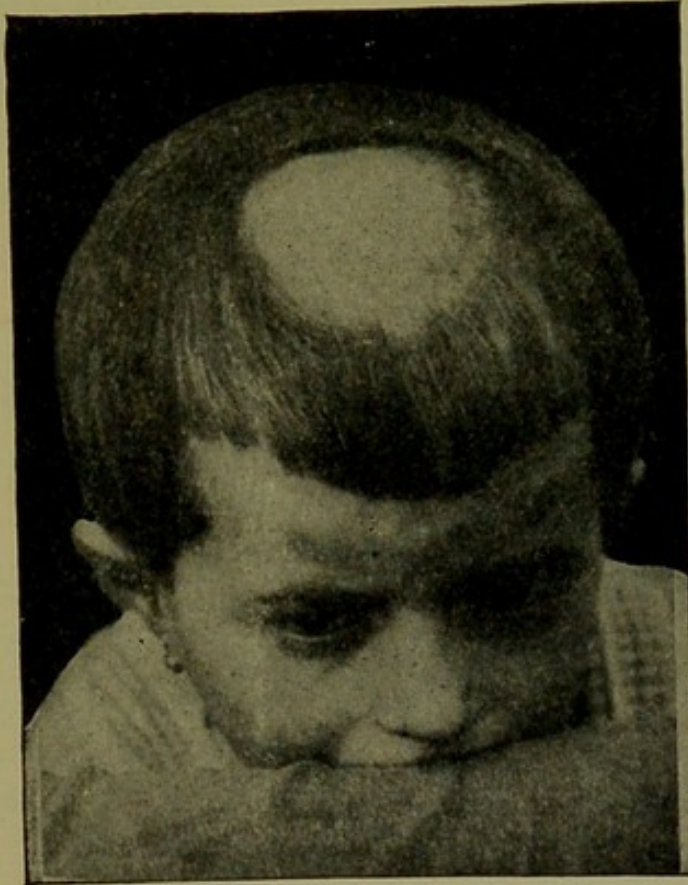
Ringworm after depilation by X-rays.
